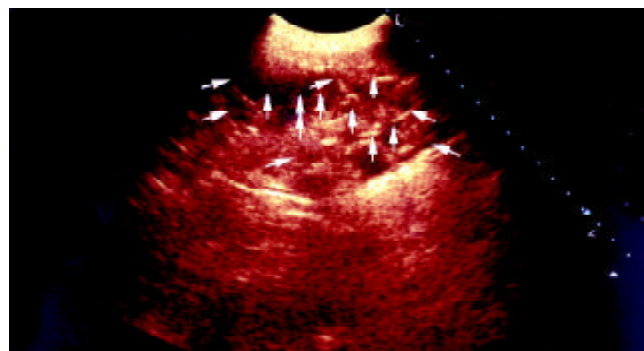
Transabdominal sonogram showed massive agglutinating adhesion between bowels, and the score is 3.
